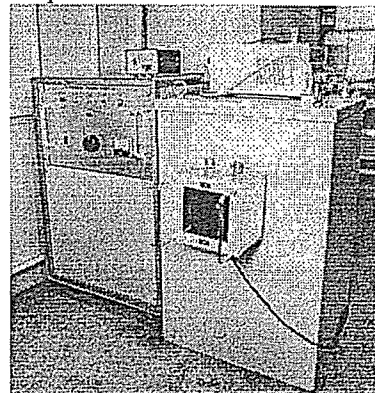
300 kV stroboscopic x-ray generator.
